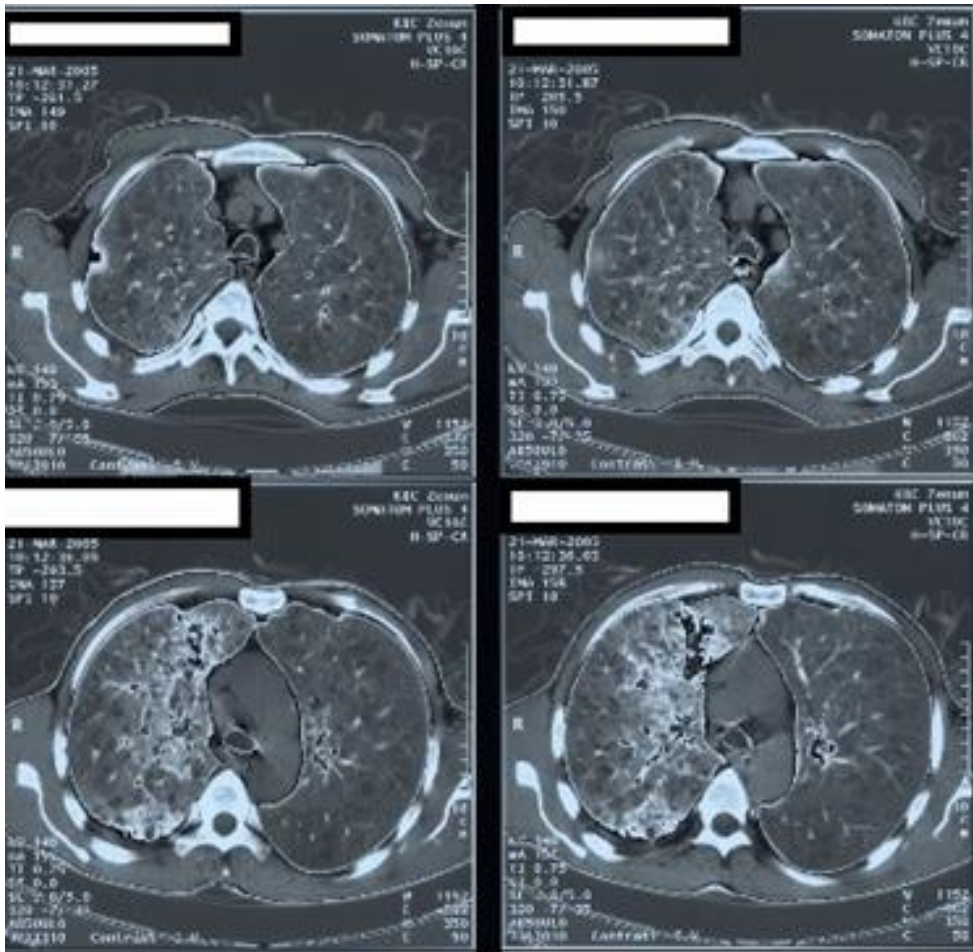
Computed tomography scan of the thorax, showing emphysema, tumor and multiple metastatic changes
